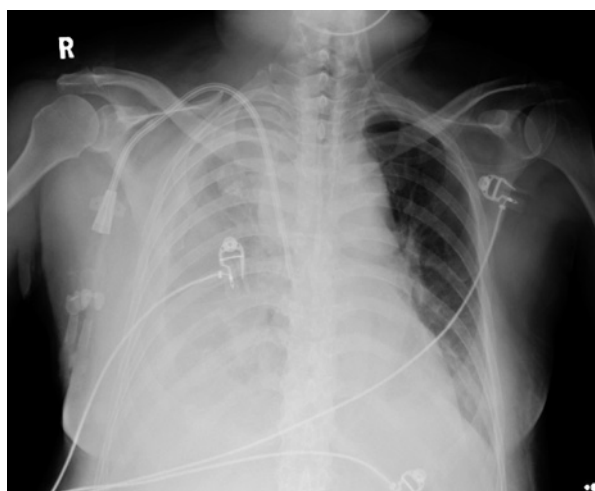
Chest radiograph at the time of dyspnea showing massive right pleural effusion.
